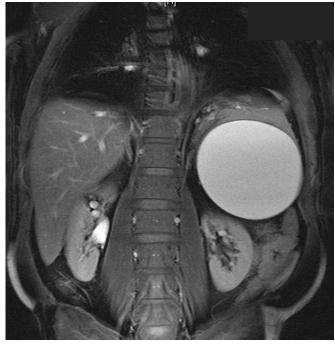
A contrast magnetic resonance image in the coronal plane demonstrates a 10-cm cyst of the spleen.
